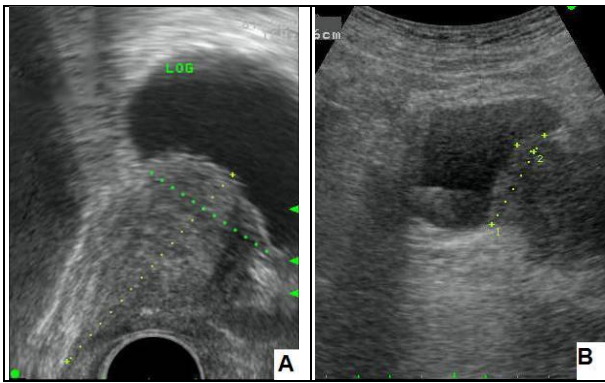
IPP measurement by TRUS (A) and abdomen ultrasound (B). IPP was measured as a vertical distance from the imaginary bladder neck line to the tip of prostate protrusion at midline sagittal view on TRUS. IPP measured by TRUS is not influenced by the amount of bladder volume, whereas IPP measured by abdominal ultrasound can be affected by bladder filling state.
